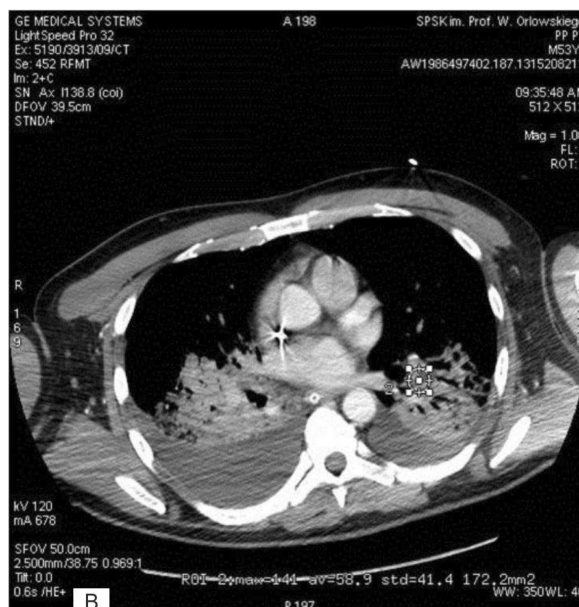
1B. Chest x-ray CT: Extensive, overlapping shadows in acini of both lungs – dense fluid in the alveoli (marked points – 1,2) – 48 HU – blood-air bronchogram visible, fine peribronchial nodules present particularly in the bottom section of the lungs, small amount of fluid in both pleural cavities (14 HU); three paratracheal lymph nodes on the right up to 20 cm, with blistering.
